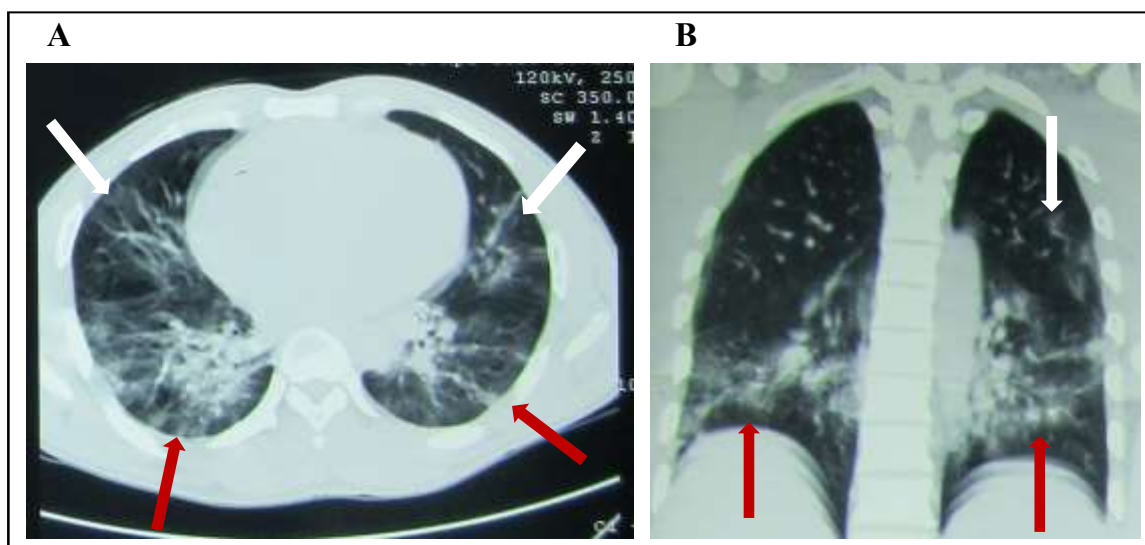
Chest CT scan showing a moderate form of COVID-19 pneumonia with lung damage between 20-25%. The axial (A) and sagittal (B) view lung windows displaying a predominant focus of subpleural consolidation mainly at the right lung base associated (red arrows) with bilateral ground glass (white arrows).
